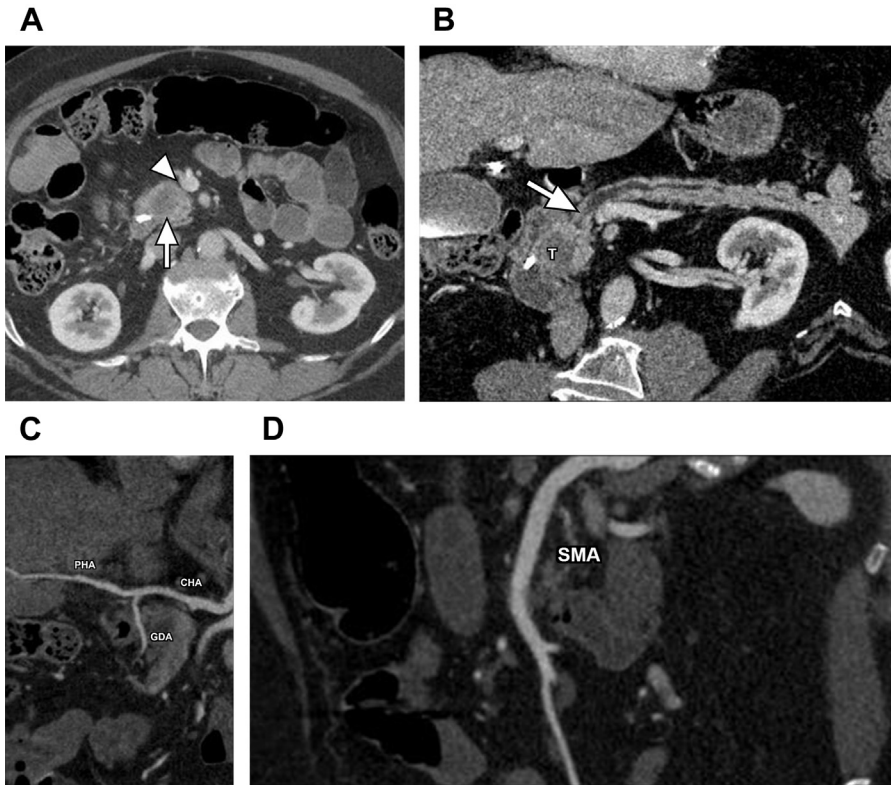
High-quality dedicated multidetector computed tomography (MDCT) evaluation of pancreatic head adenocarcinoma. (A) Axial contrast-enhanced MDCT image through the pancreatic head demonstrate an ill-defined hypodense mass (arrow) consistent with pancreatic adenocarcinoma. There is no contact with the adjacent superior mesenteric vein or artery (arrowhead), suggesting a resectable tumor. (B) Curved reformatted image through the pancreas demonstrate the level of pancreatic duct obstruction (arrow) and outlines the edge of the tumor (T). (C) High-resolution curved reformatted image through the celiac axis branches improves the assessment of the peripancreatic vessels confirming the lack of tumor contact with the common hepatic artery (CHA), gastroduodenal artery (GDA), and proper hepatic artery (PHA). (D) Additional curved reformat through the superior mesenteric artery (SMA) demonstrate lack of tumor contact.
